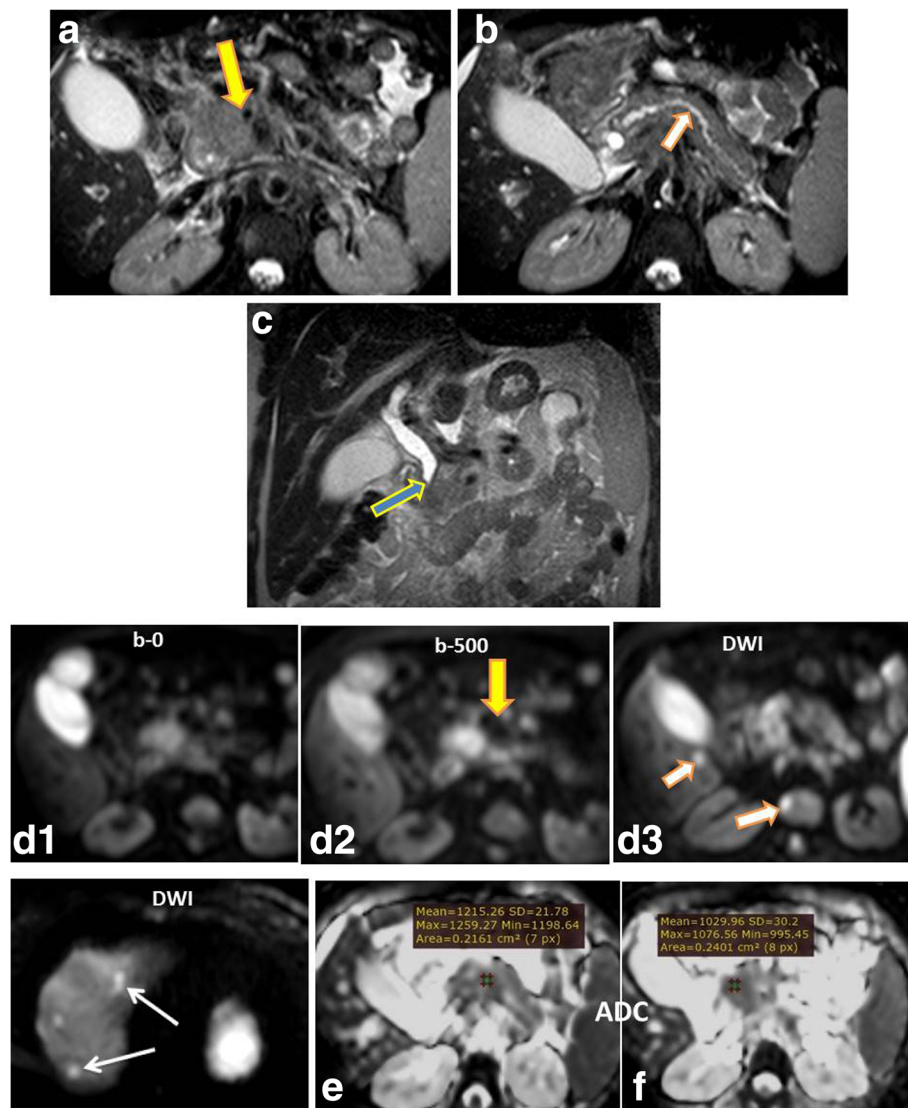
A 73-year-old female patient presented by obstructive jaundice. a–c Conventional images (axial and coronal T2WI) showed isointense signal intensity lesion involving the pancreatic head with encasement of the mesenteric vessels $> 180^\circ$ (yellow arrow). Dilated CBD down to its lower end (arrow in c). d–f DWI and ADC maps revealed truly restricted pancreatic head mass with increased brightness with increasing of the *b* value denoting its malignant nature. The vascular encasement here appeared to be $< 180^\circ$ (resectable lesion). Multiple hepatic (d4) and bone (d3) deposits are detected rendering the lesion unresectable. The ADC value of the lesion ranged from 1.0 to $1.2 \times 10^{-3} \text{ mm}^2/\text{s}$
